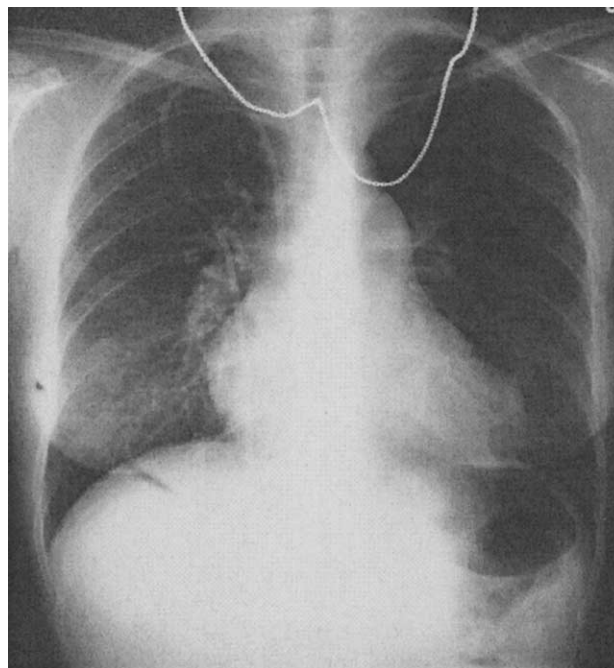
Chest x-ray demonstrating enlarged pulmonary arteries and cardiomegaly.
